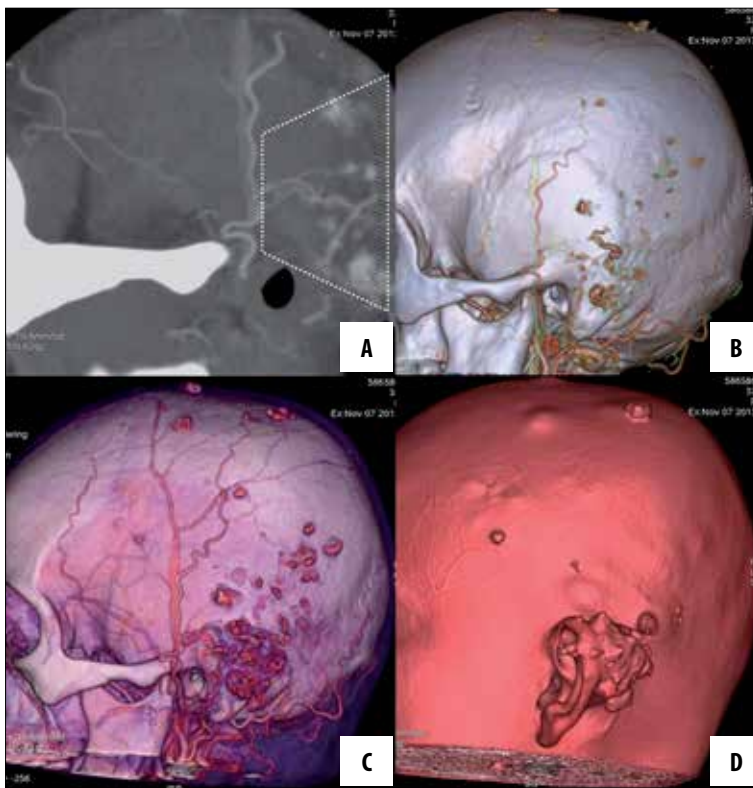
The demonstrative features revealed on reformatted and 3D CT images. A sagittal maximum intensity projection (MIP) reformatted image (A) revealed patchy enhancement at in the venous drainage areas (dashed-line area) around the concomitant arteries. On the series with an increased contrast dose (B–D), the location and distribution of soft tissue masses became clearer.
